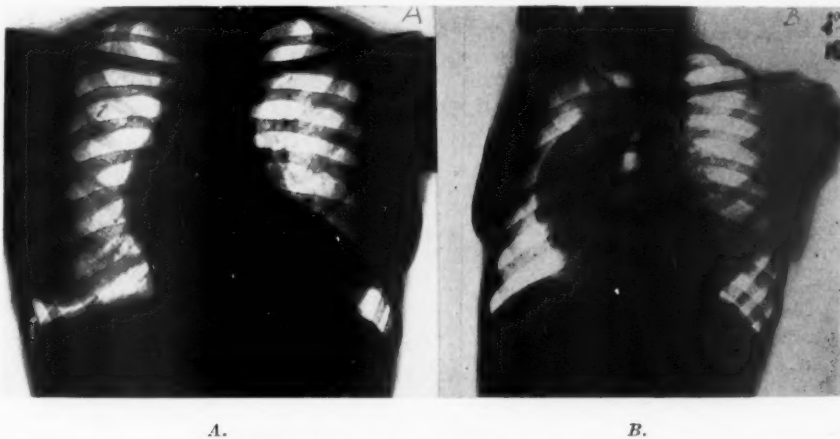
A, Roentgenogram of the heart in Case 1, in the anteroposterior view, showing marked enlargement of the left ventricle, absence of the aortic knob, aneurysmal dilatation of the supraventricular portion of the aorta, and erosion of the ribs on the right side only. B, Roentgenogram of the heart in Case 1, in the left oblique position, showing enormous aneurysmal dilatation of the supraventricular portion of the aorta and narrowing of the arch in proximity to the spinal column. Note the enlargement of the aorta immediately below the constriction.
